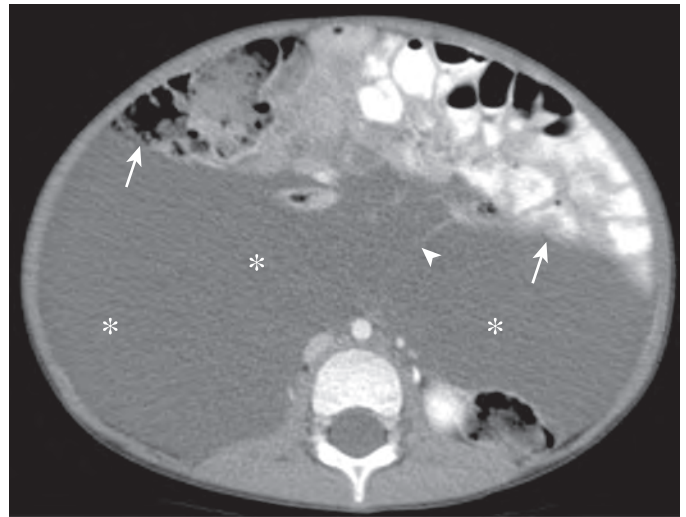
Mesenteric lymphatic malformation. A 3-year-old boy with a mesenteric lymphatic malformation. Axial postcontrast CT images of the abdomen show a large hypoattenuating mass in the abdomen and pelvis (asterisks) with a few thin septations (arrowhead), which causes anterior displacement of bowel (arrows).
